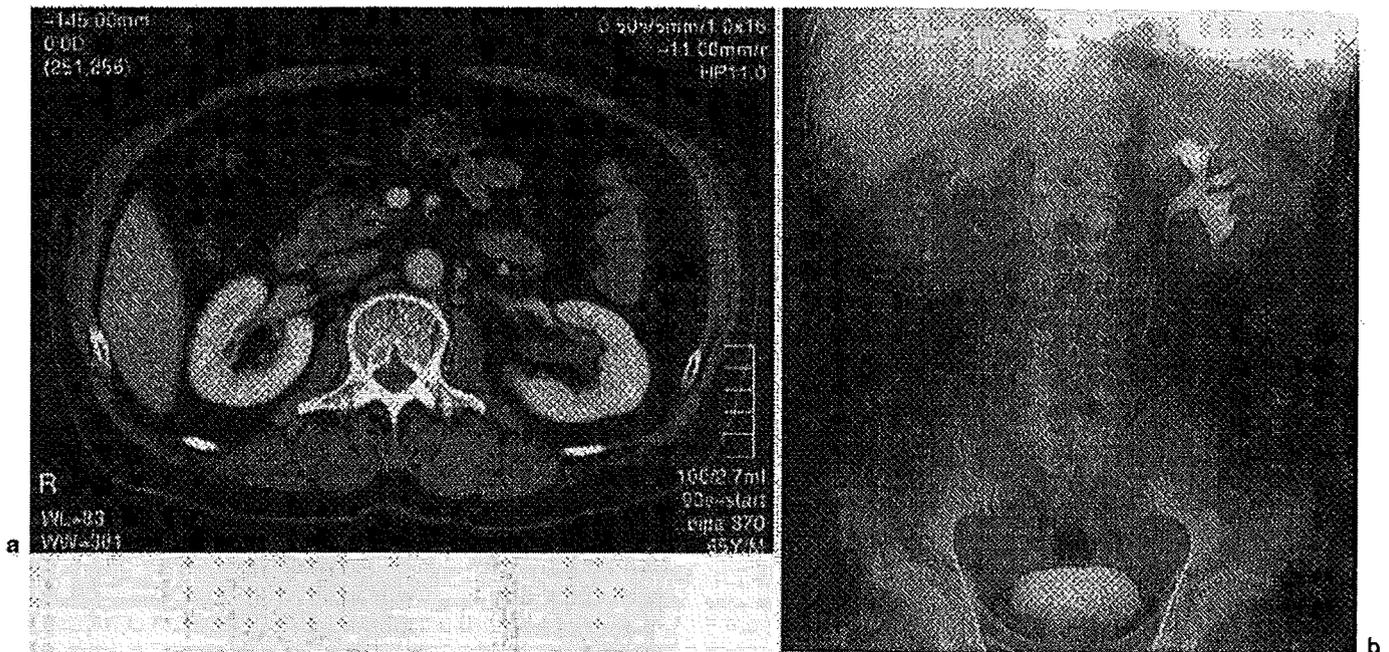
a Preoperative enhanced computed tomography scan showing left hydronephrosis. b Intravenous pyelography. Drip infusion pyelography confirmed a left ureteral defect
